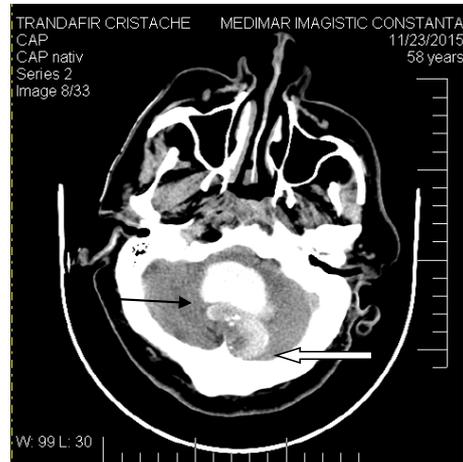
Preoperative aspect: Cranial CT Scan with contrast substance: Vermian posterior, left paravermian and in the fourth ventricle tumoral lesion, moderate heterogeneous with a hypodense part having 3 calcified microopacities (white arrow). Anterior vermian and left paravermian haemorrhage (black arrow). The 2 lesions together were compressive on the mesencephalon and on the adjacent cerebellar hemispheres
